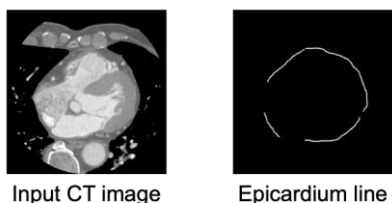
Epicardium in the CT image.
